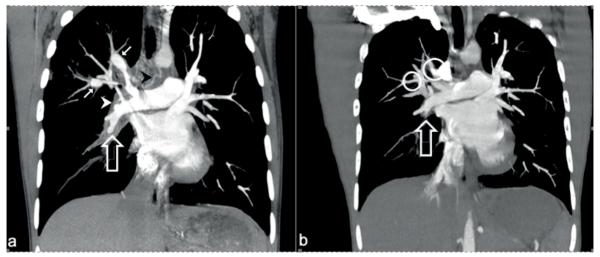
Coronal reformatted images of CTA. a) At diagnosis: Aneurysms of upper lobar segments (white arrows) and thrombotic occlusion of basal trunk (open arrow) of the right pulmonary artery, perivascular soft tissue thickening like sheath (white arrowhead) due to inflammatory infiltrates of vasculitic process and enlargement of the bronchial arteries (black arrowhead). b) After treatment: Regression of vasculitic process: disappearance of aneurysms (circles) and soft tissue thickening. The segmental branches of right pulmonary artery are patent and normal calibration with the exception of occluded basal trunk (open arrow).
